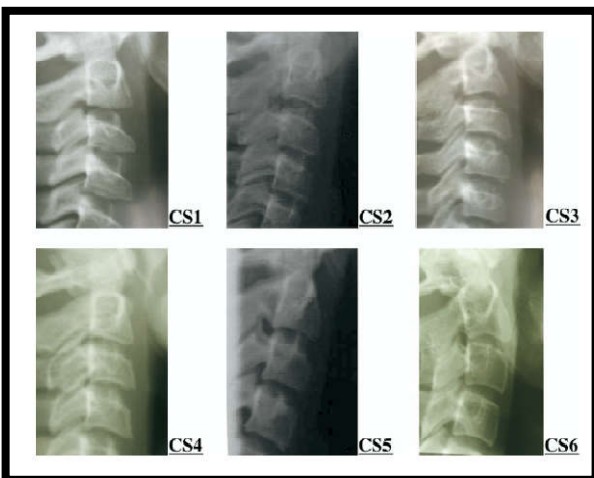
Fig Radiographs used as reference for the 6 cervical vertebrae stages
